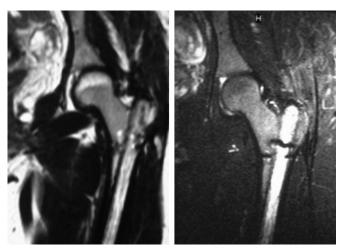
MRI scan of the left hip and proximal femur 3 days after nail removal. The nail was removed 15 months after the fracture had occurred. The position of the nail is clearly demarcated on T1 images, giving bright signal on T2 images. There is no evidence of femoral head pathology.
